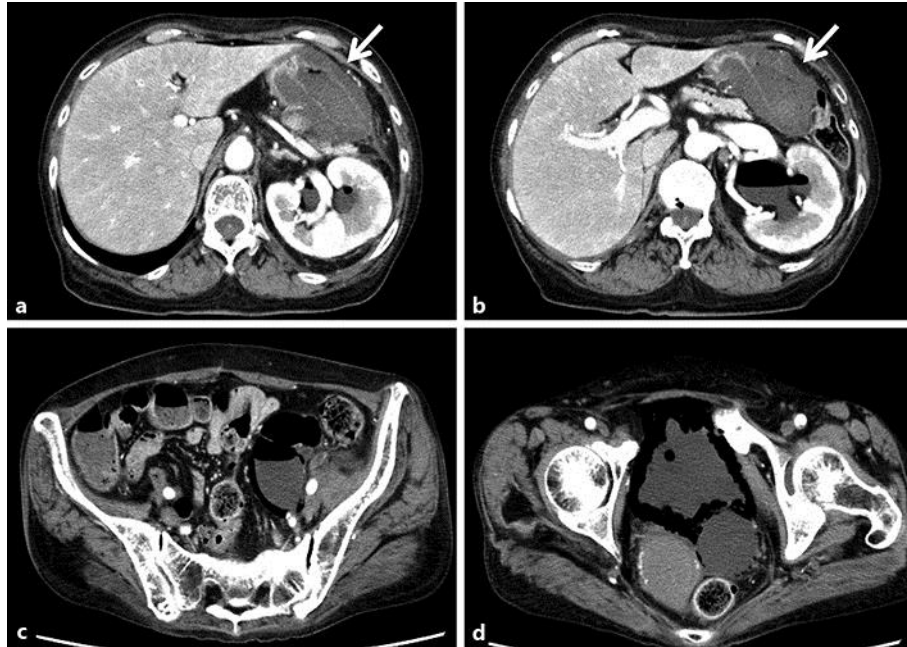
Contrast-enhanced computed tomography images showing the enlargement of the left kidney, renal pelvis, and ureter (a–c) and gas accumulation within the renal pelvis, ureter, and bladder (a–d). The patient's right kidney is absent, and a thickened gastric wall can be observed (arrows).
